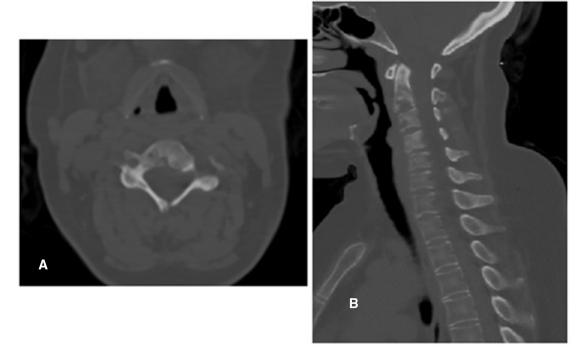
Eight months after treatment. (A) Spine computed tomograpphy (CT) image with axial cut showed partial calcification of the lytic lesion in C4. (B) CT image with sagittal cut showed partial calcifications in the other lesions.
